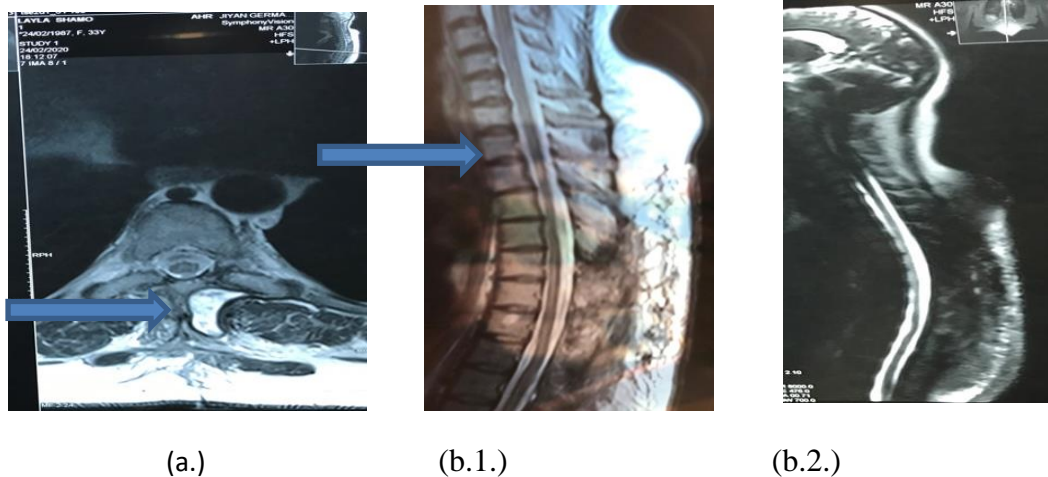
Post-operative MR images, Pre- and post-contrast, T2W phases (a-b).
